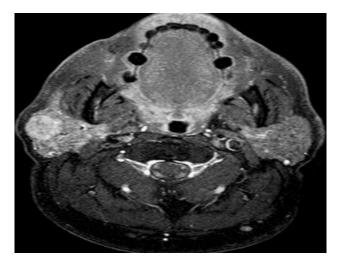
Parotid MRI, axial section after gadolinium administration.
